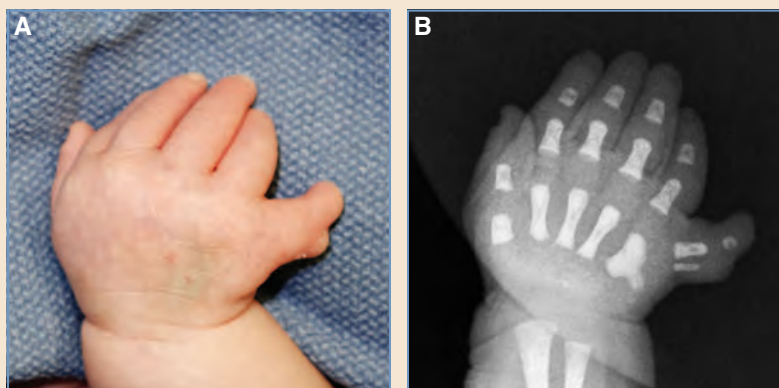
Ulnar polydactyly. A, This clinical presentation is not within the classification. B, A radiograph of the same patient.
